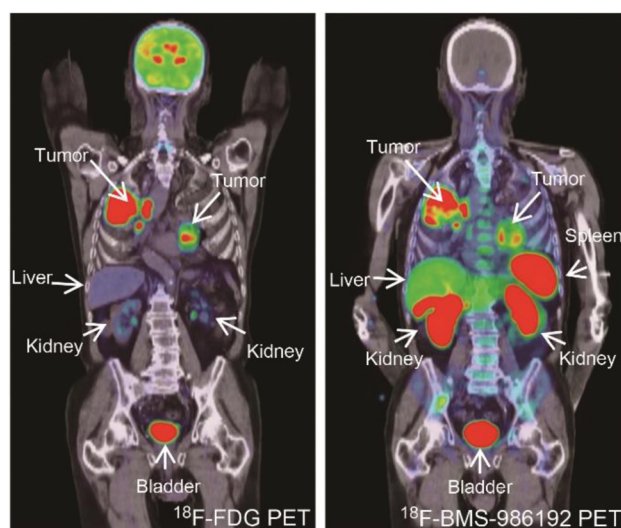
PD-L1-targeting adnectin probes for clinical PET imaging. Notes: a patient with advanced NSCLC (PD-L1 expression > 50%) was administered with <sup>18</sup>F-FDG PET (left) and <sup>18</sup>F-BMS-986192 adnectin PET tracer (right); compared to the FDG tracer, the PET image of adnectin showed high tumor-to-background contrast and heterogeneous uptake at tumor sites. Adapted from ref. 100. Abbreviations: NSCLC, non-small-cell lung carcinoma; and PD-L1, programmed death-ligand 1.
